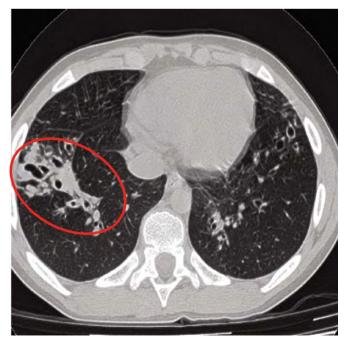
This high resolution CT image clearly shows the heterogeneity of cystic fibrosis lung disease. An area of localized end-stage lung disease (*red ellipse*) can be seen next to areas that are apparently normal.
